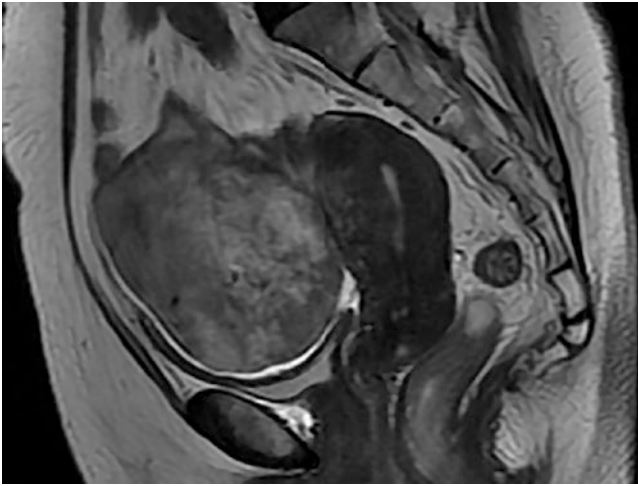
Sagittal T2-weighted image showed the mass was heterogeneous. It had marked enhancement equal to myometrium after contrast enhancement
